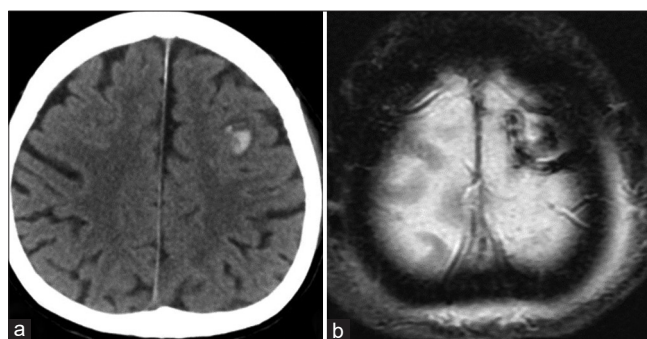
(a) Computed tomograms showing left frontal lobar hemorrhage 1 cm in diameter. (b) T2*-weighted images revealed a new thrombus in the left cortical vein.
